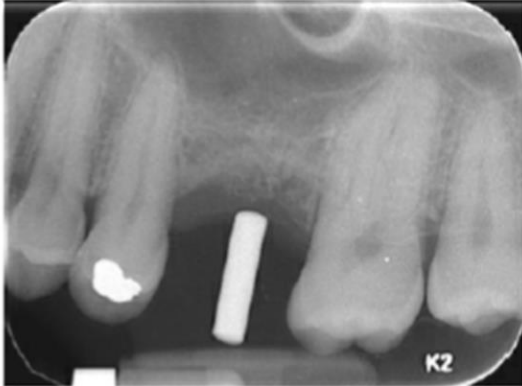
Periapical image of a potential implant site in the posterior left maxilla. An imaging guide containing a cylindrical radiopaque marker has been inserted intraorally to depict the desired angle of implant placement.
